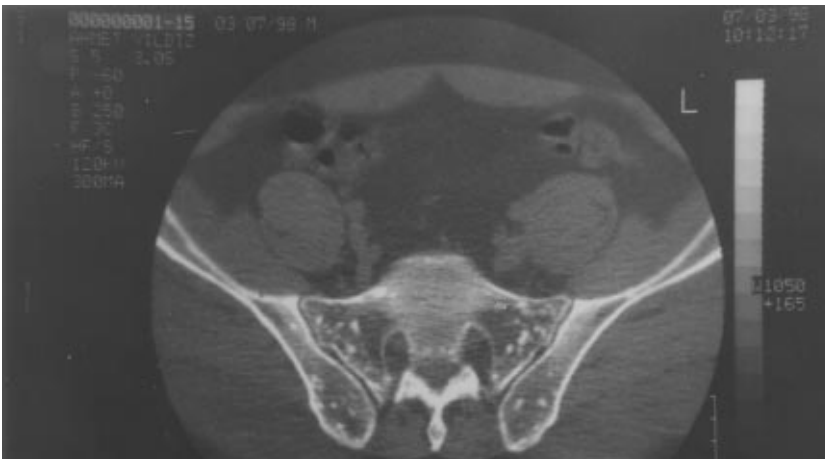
Computed tomography imaging showing numerous, symmetric, small, well-defined, circular sclerotic bone lesions characteristic for osteopoikilosis.
